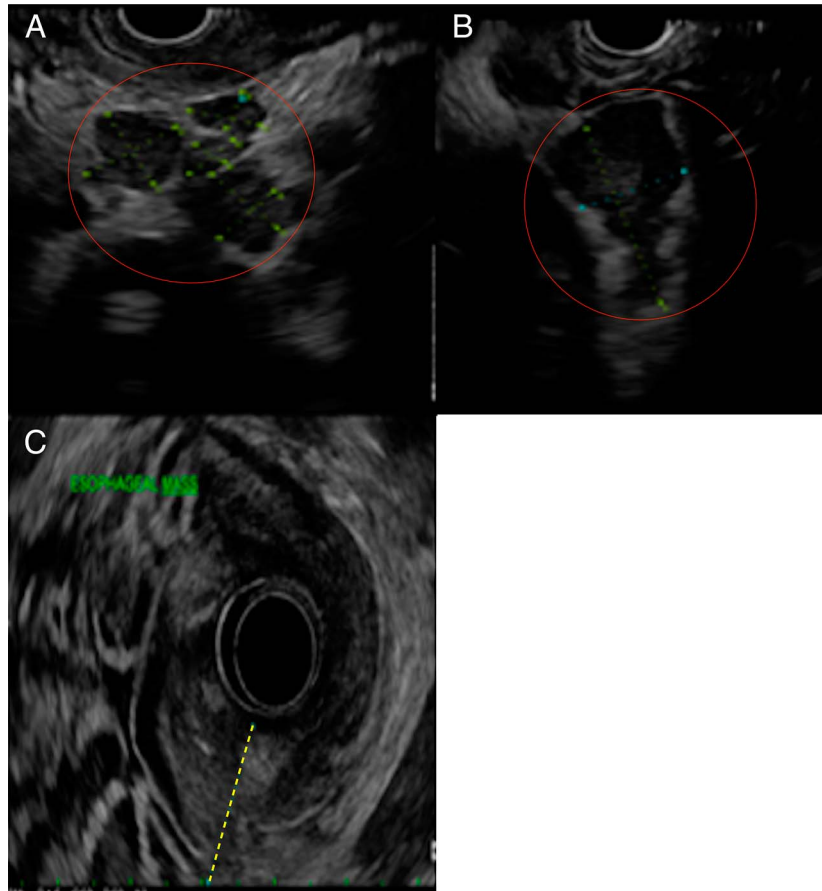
Endoscopic ultrasound with findings of lymphadenopathy (red circle) in the (A) perigastric region largest measuring 13×14 mm, (B) porta hepatis region measuring 31.9×15.6 mm, and a (C) noncircumferential, hypoechoic and heterogenous esophageal mass with maximum thickness of 24 mm (dashed yellow line).
